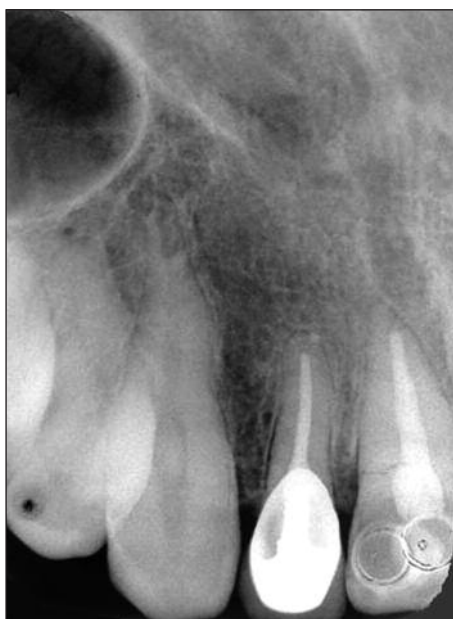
A five-years follow-up radiograph showing no root resorption and marginal bone loss.
